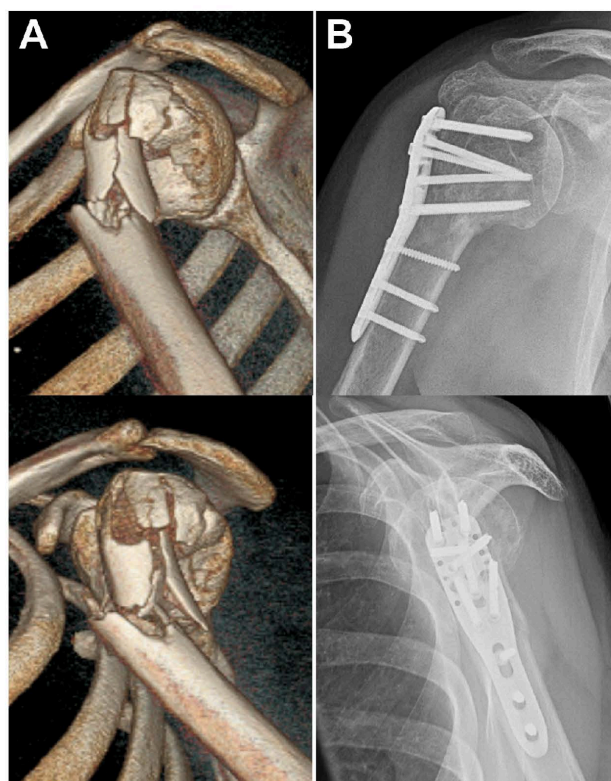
(A) Three-dimensional computed tomography scan shows a comminuted proximal humeral fracture (AO11-B2) in a 65-year-old woman. (B) Complete bony healing 6 months after open reduction and internal fixation with a PHILOS locking plate (Synthes, Oberdorf, Switzerland) and FiberWire (Arthrex, Naples, FL, USA) sutures of the tuberosities.
